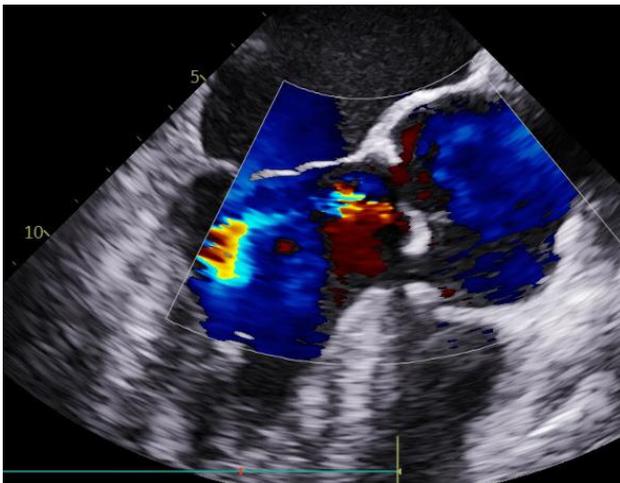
Intraoperative Transesophageal Echocardiography (TEE) showing moderate to severe aortic insufficiency
